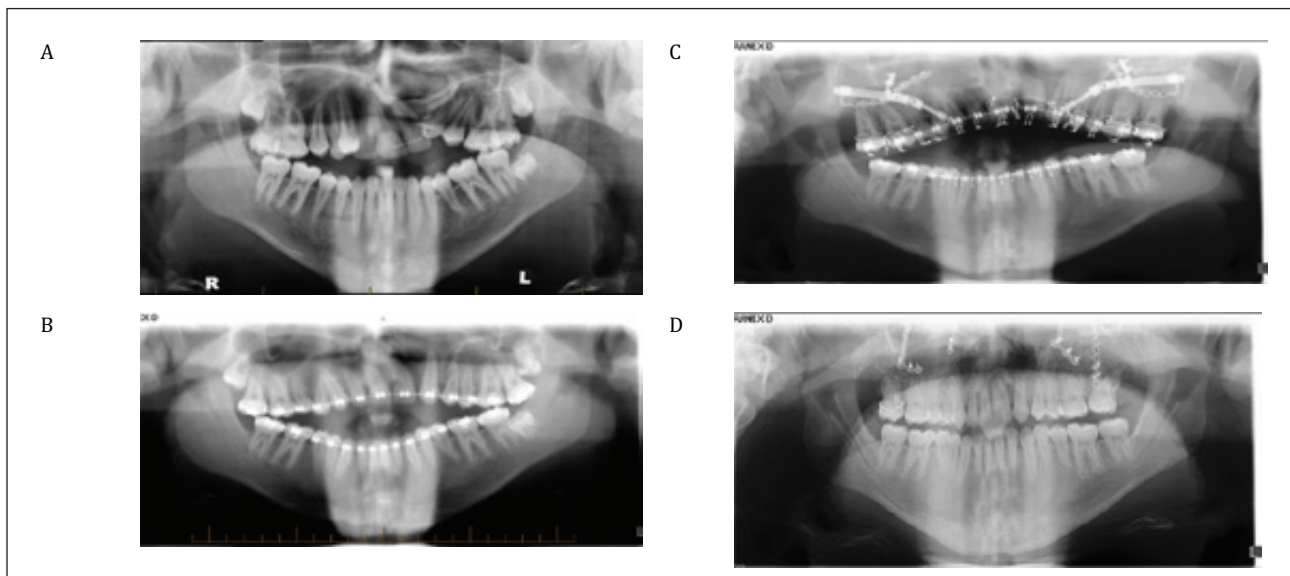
Panoramic radiographs (A) Pre-orthodontics (B) Pre-distraction placement (C) Pre-distraction activation with palatal acrylic splint in place (D) Orthodontic appliance removal.
